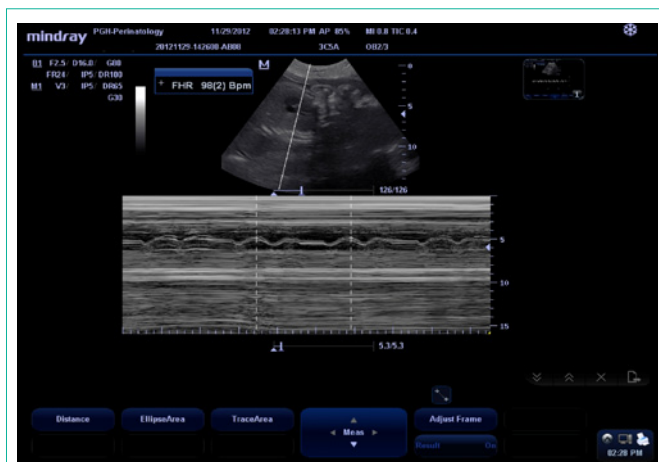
Bradycardia of 98 bpm noted on routine follow-up ultrasound scan of Case 3.
